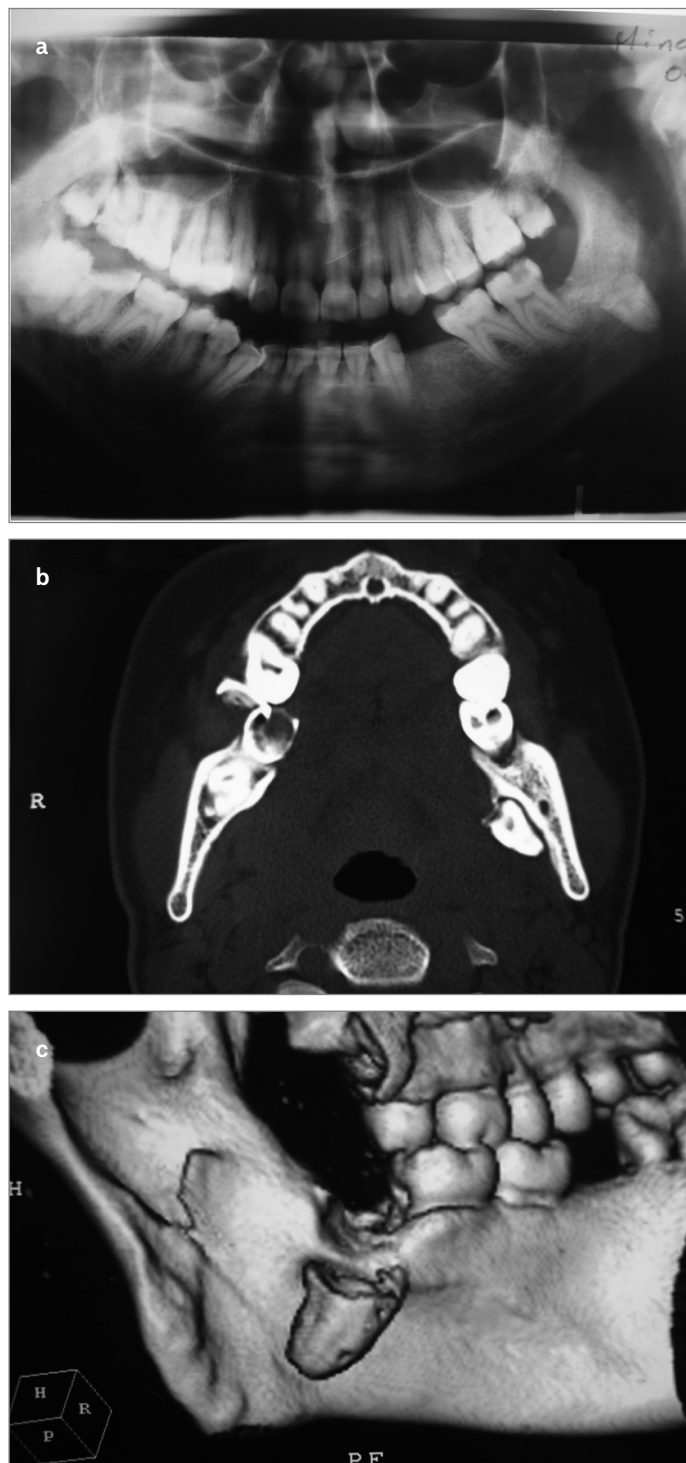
a-c. Preoperative panoramic radiograph of the patient (a). Computerized tomography showing the tooth (b). Three-dimensional computerized tomography of the patient (c)
